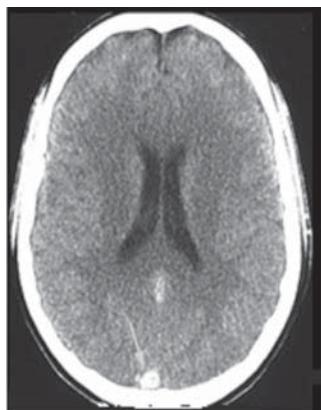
Unenhanced CT scan. Dense triangle in a recent S.S.S. thrombosis arrow. The thrombus is hyperdense. (Man, 44 years old, with headache, papilledema, left sixth nerve palsy)
